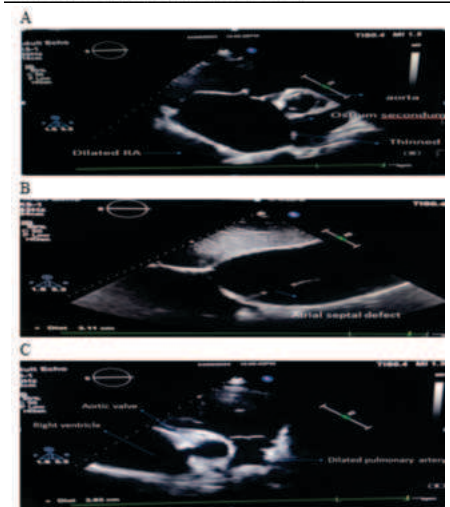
A: Parasternal short axis shows dilated right atrium with ostium secundum and aorta and thinned interatrial septum. B: shows Atrial septal defect. C: Dilated and atrialaziation of right ventricle with dilated pulmonary artery with no pulmonary hypertension.
